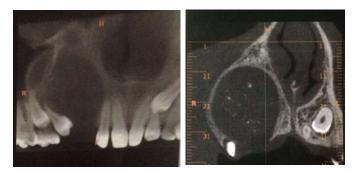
CBCT imaging reveals inverted pear shaped radiolucency with radiopaque masses and approximation with maxillary sinus and nasal floor
